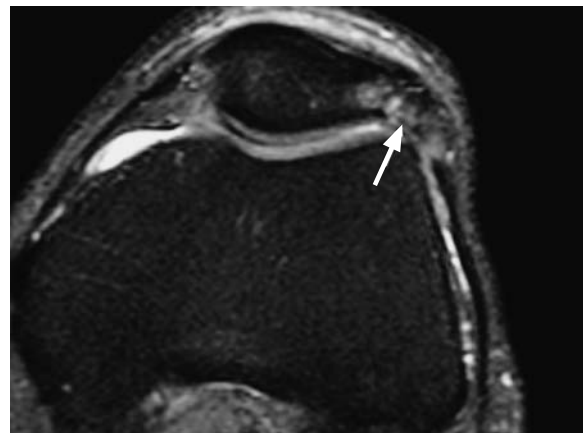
Bipartite patella. Axial fat suppressed MR image showing bipartite patella (arrow) with edema either side of the division between the two ossicles
